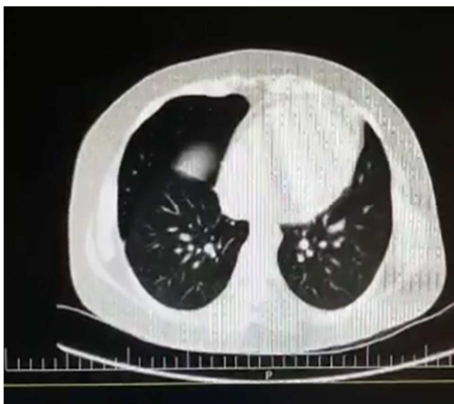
HRCT of twins' mother after recovery from Covid-19. Mild ground glass changes are seen in peripheral area.
